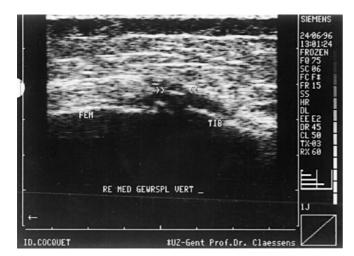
Sonography shows a localized edematous zone in the MCL following Biofix arrow application for the meniscal rupture in the middle one-third
